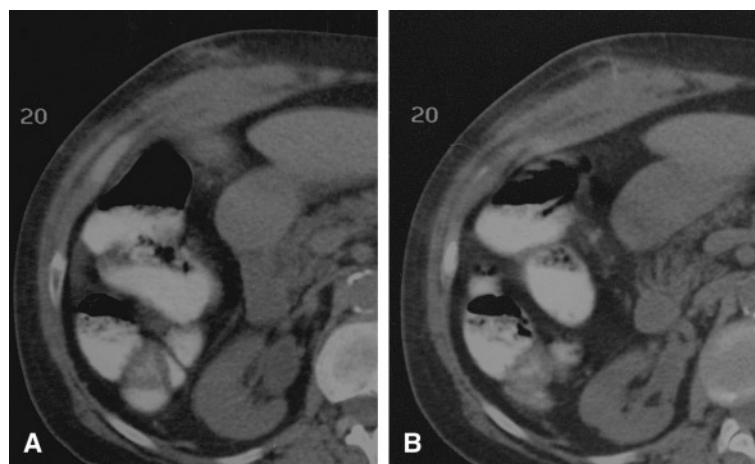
A, B Unenhanced CT demonstrates poorly defined infiltrative process from the subcutaneous tissue to the peritoneal surface.
